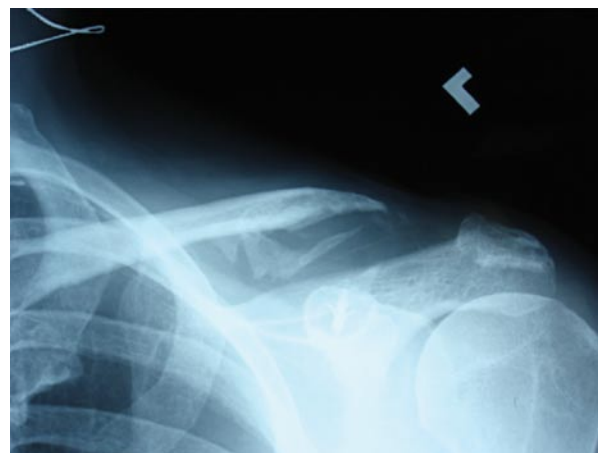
Twenty-five months after surgery, x-ray with 10-lb weight in left hand shows stable mild increase in coracoclavicular distance.
